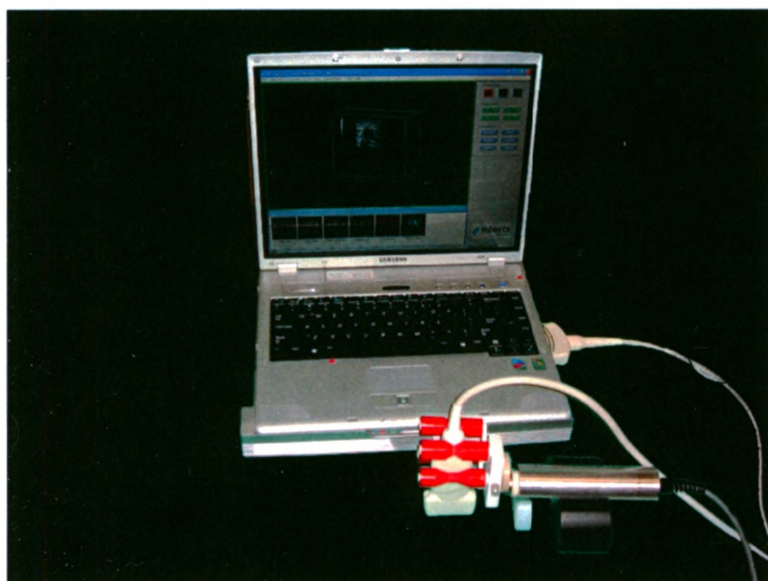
Terason t3000 3D US system. Portable ultrasound unit attached to a hand held scanner with attached transducer.
